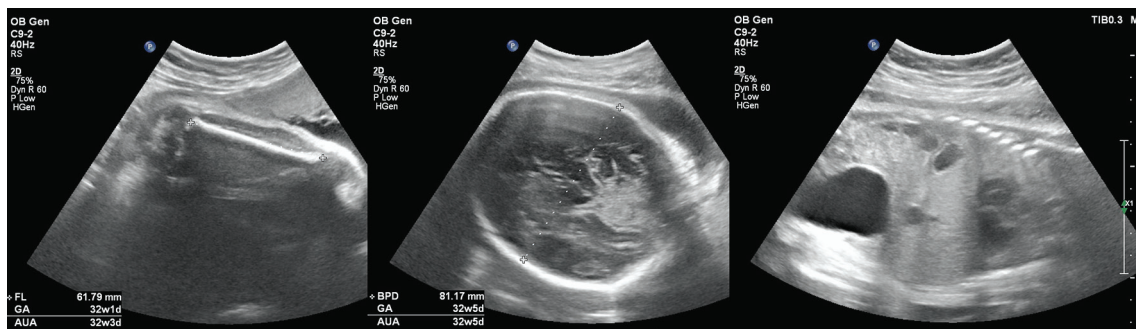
Transabdominal ultrasound in the third trimester showed a live fetus with normal growth.
